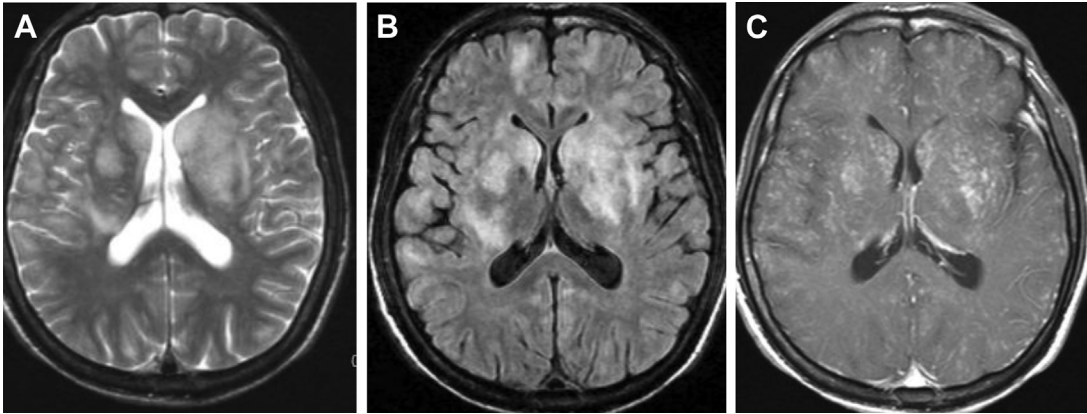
NTM infection. Axial T2-weighted MR imaging (A) and FLAIR MR imaging (B) show multifocal patchy signal abnormality in the bilateral subcortical white matter and deep gray matter. Axial T1-weighted postcontrast MR imaging (C) shows widespread infiltrative contrast enhancement.
